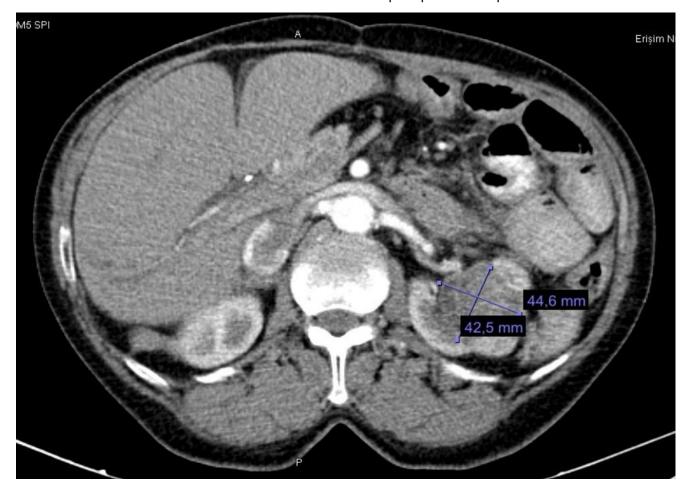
CT image of the case.
